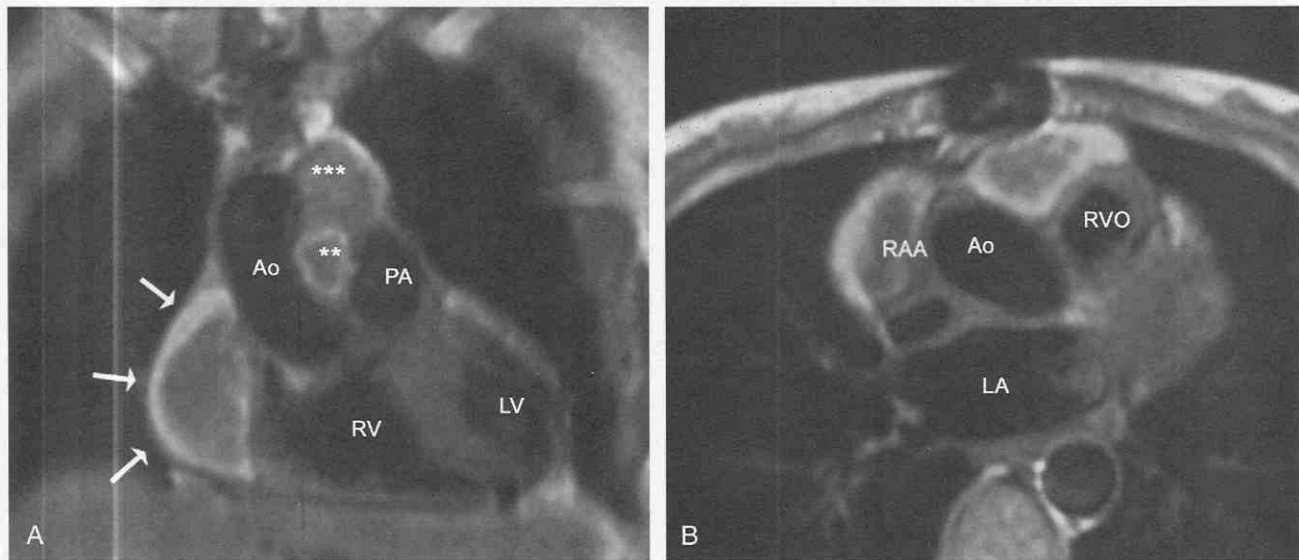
MR images obtained from a 53-year-old man who received a heart transplant 36 hours earlier, now with a widened mediastinum and cardiac silhouette. *A*, Coronal spin-echo acquisition shows a rim of increased signal intensity (arrows) surrounding the lateral border of the right atrium, above the top () of the main pulmonary artery (PA), and in the space between the ascending aorta (Ao) and pulmonary artery (*). LV, left ventricle; RV, right ventricle. *B*, Axial section through the right ventricular outflow tract (RVO). Increased signal intensity surrounds the right atrial appendage (RAA) and is insinuated between the ascending aorta (Ao) and RVO. LA, left atrium.
